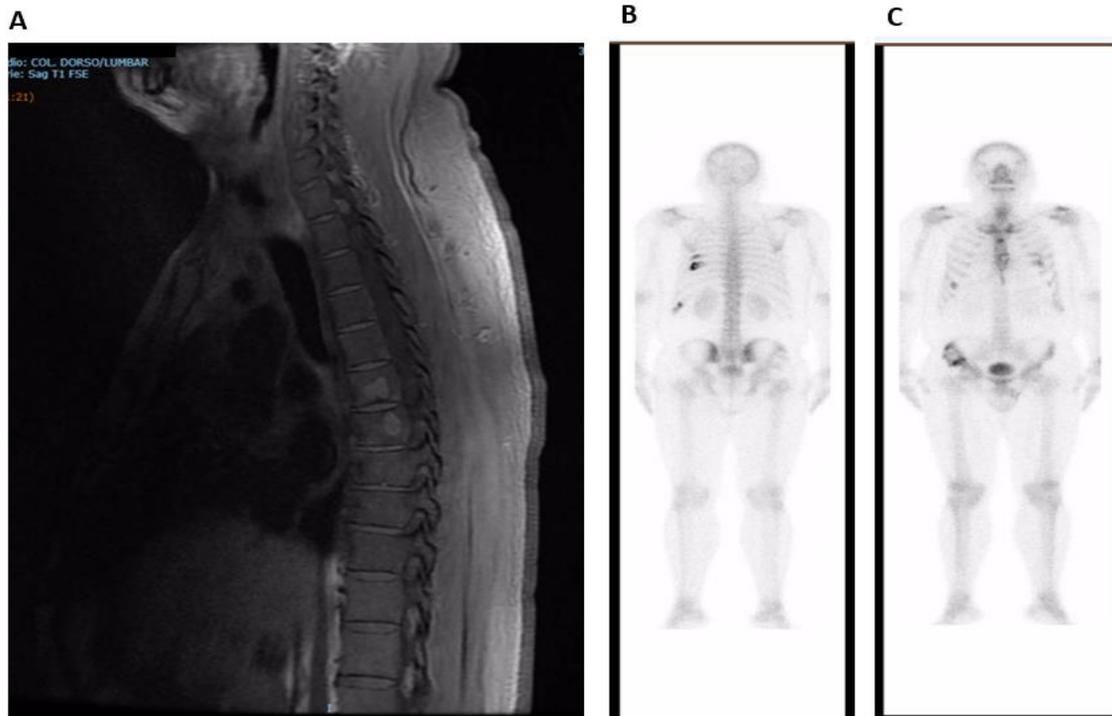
Sagittal spine magnetic resonance (A) and planar bone scintigraphy (B and C) for patient 3 upon admission to institute, showing multiple hypercapturing images corresponding to multiple myeloma activity, including in jaw.
